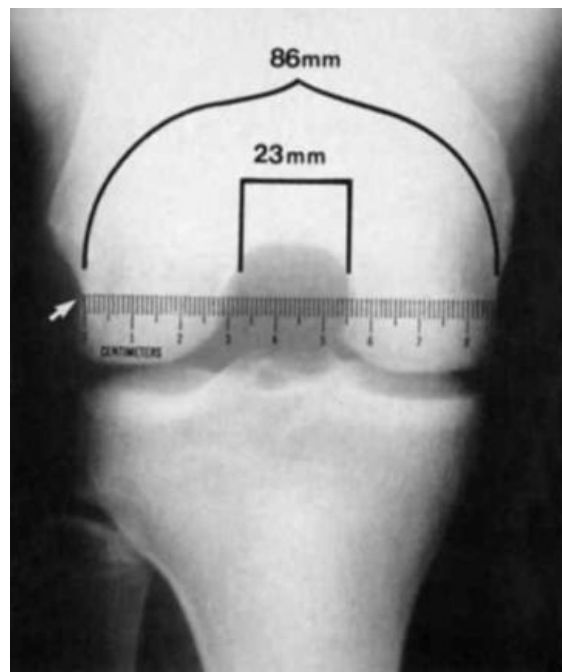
Assessment of intercondylar notch width ratio on a radiograph
